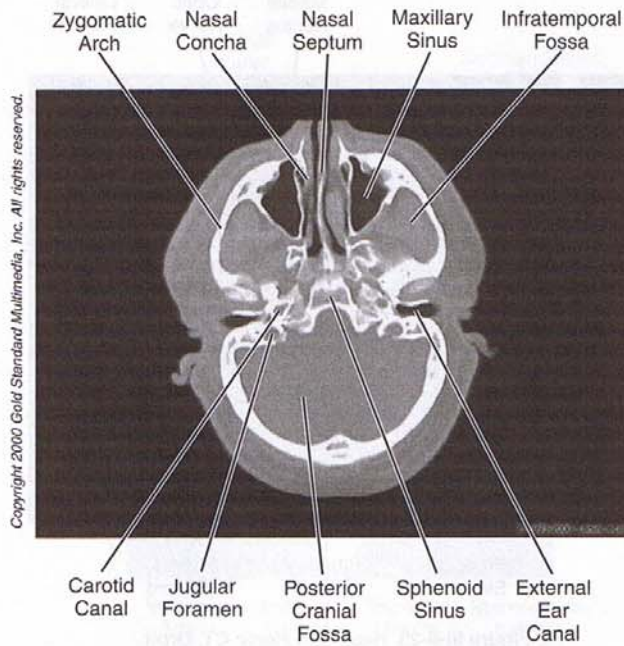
Head and Neck: CT, Skull
